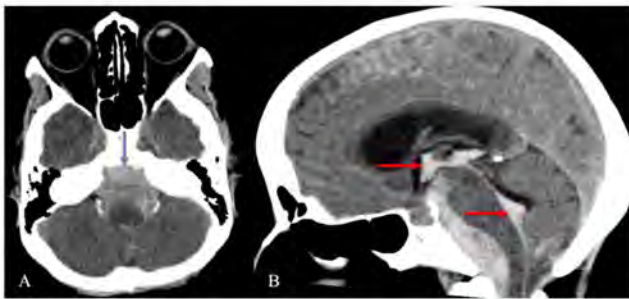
Non-Contrast CT Head Demonstrating Diffuse Subarachnoid Hemorrhage With Intraventricular Extension
